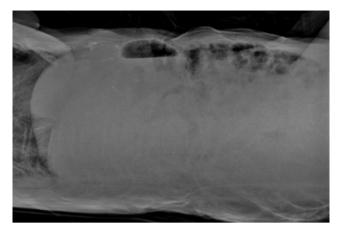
Decrease in the width of the colon loops and loss of air-fluid levels on abdominal radiography (after treatment).
